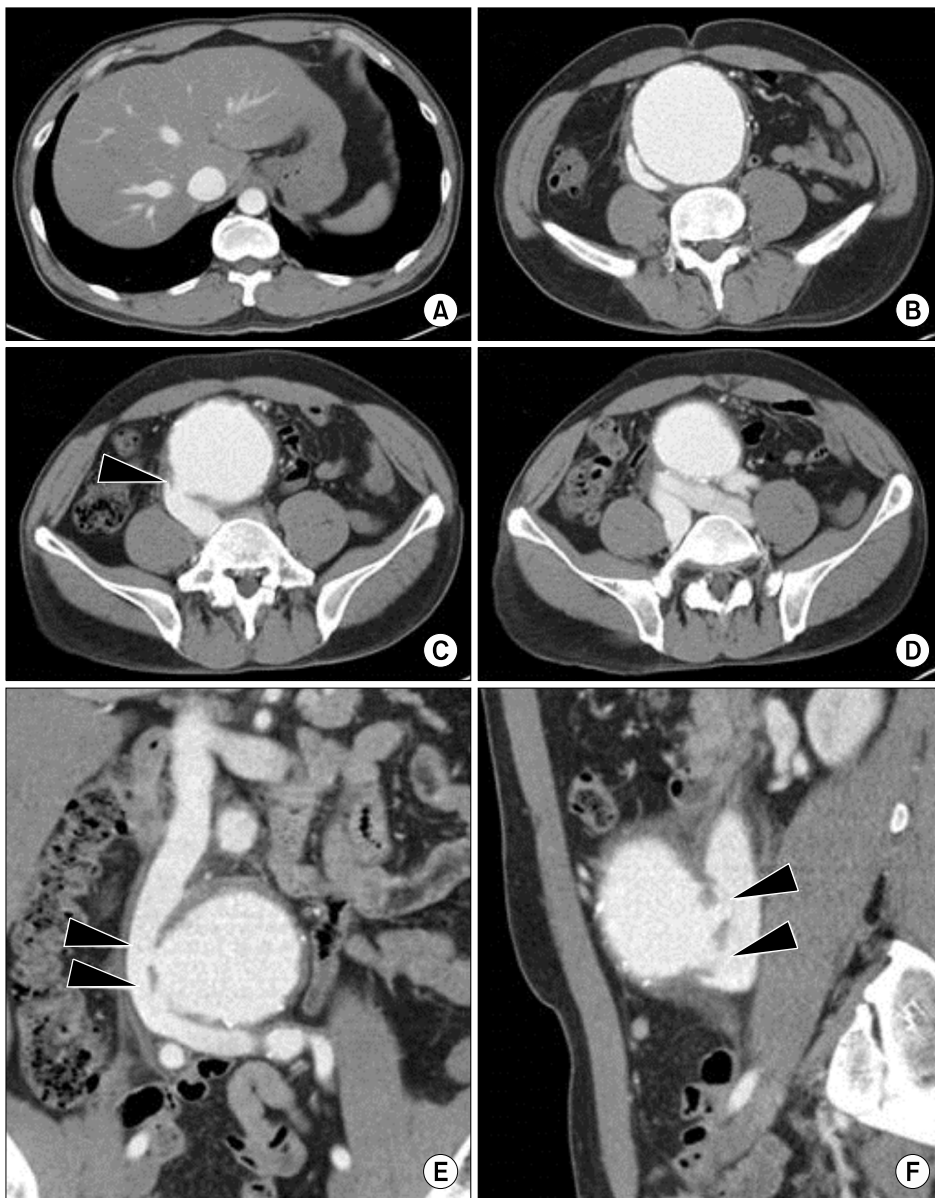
Contrast-enhanced abdominal computed tomography shows the abdominal aorta and its relation to the IVC. (A) Early enhancement of the hepatic vein and the IVC in the arterial phase is observed. (B) The IVC is collapsed because of the abdominal aortic aneurysm with a maximum diameter of 9 cm. (C, E, F) A wall defect and fistulous communication (arrowheads) between the aorta and the IVC are revealed on the axial plane, coronal plane, and sagittal plane, respectively. (D) Early enhancement and dilatation of both common iliac veins are revealed. IVC, inferior vena cava.
